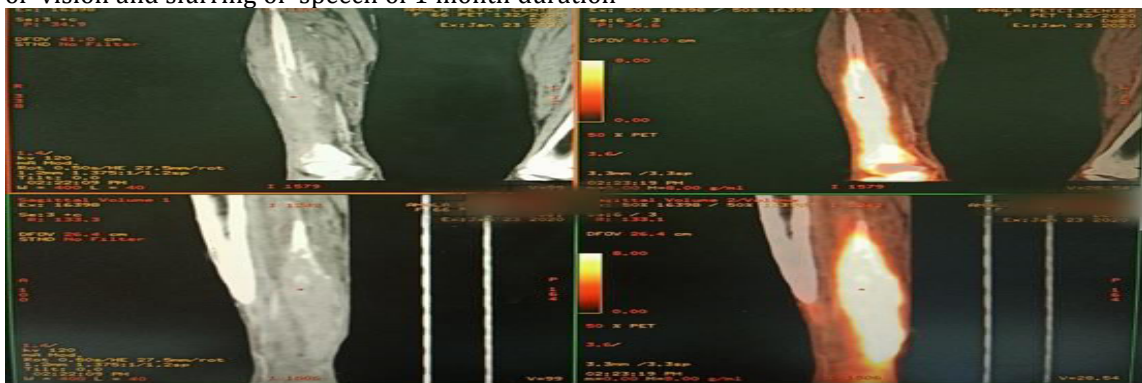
PET-CT image showing FDG avid destructive lytic lesion with soft tissue is seen involving mid & lower right fibula.
